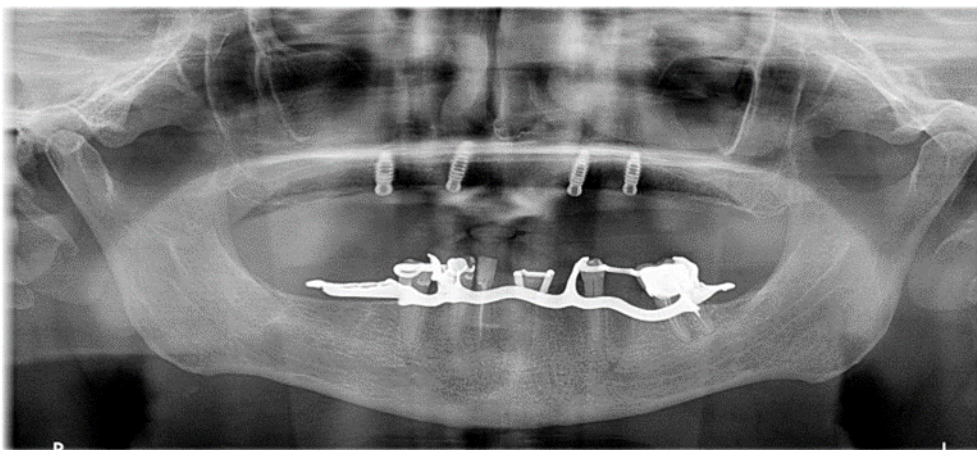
Post-implant surgery orthopantomography.*
